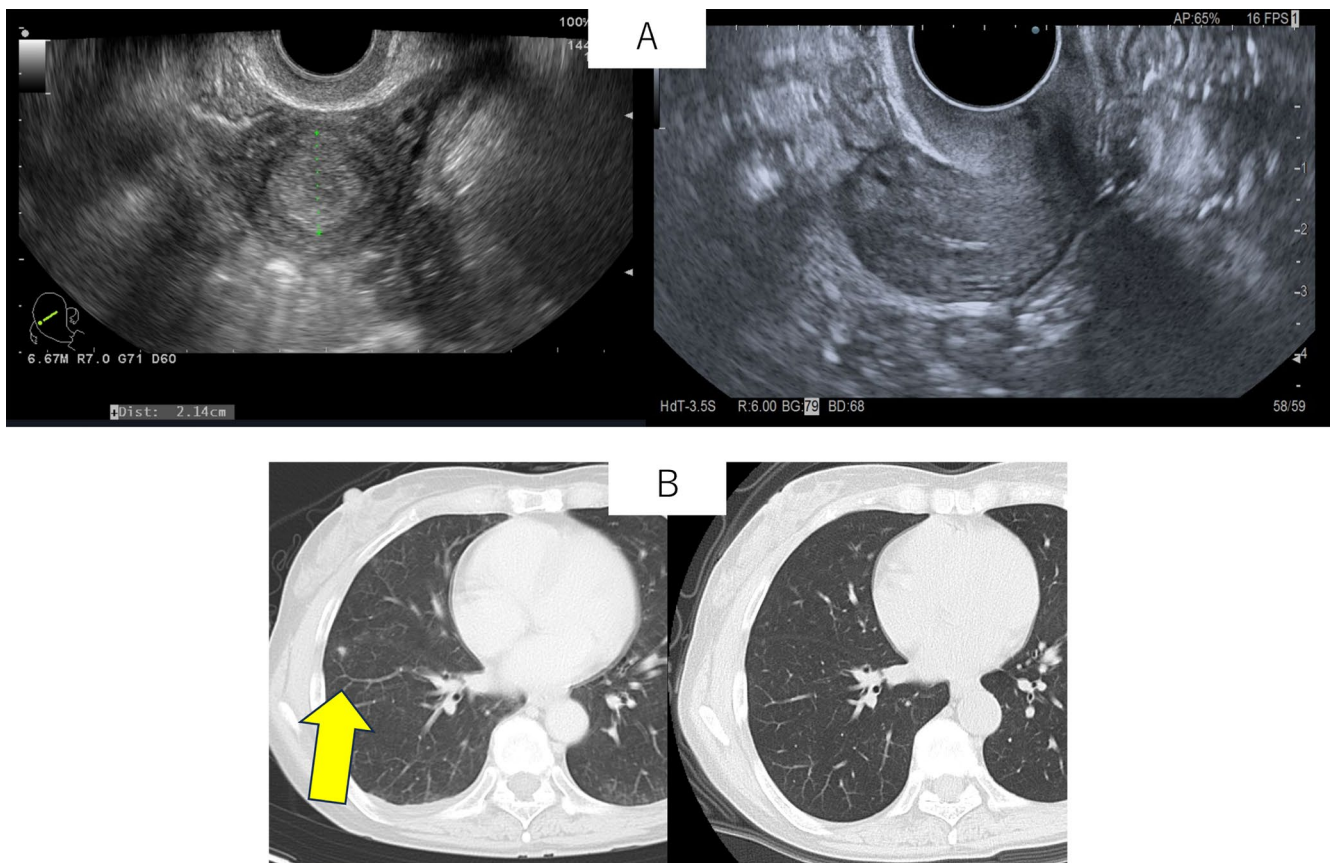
Imaging findings before treatment and prior to surgery. (A) Transvaginal ultrasonography before treatment (left) and prior to surgery (right), showing marked reduction of the intrauterine mass. (B) Chest CT before treatment (left) and prior to surgery (right), showing resolution of pulmonary metastases with residual scar-like opacity.
